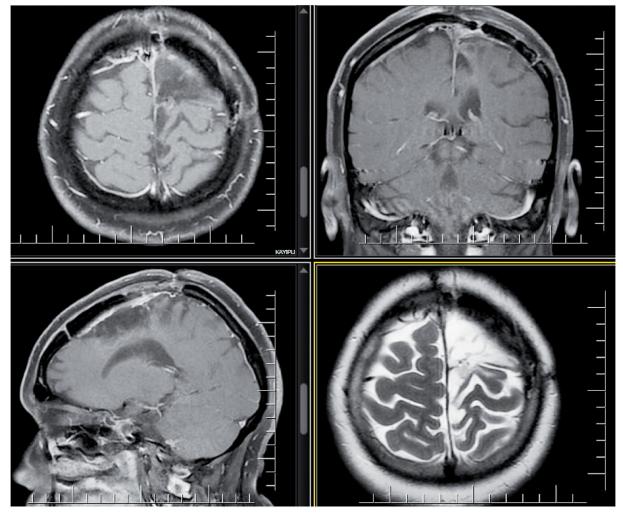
Post-operative MRI after the third operation.
